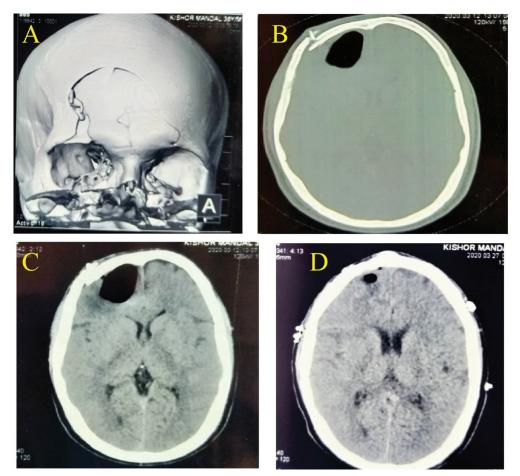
Preoperative 3D CT image showing frontal bone depressed fracture(R>L) (A), axial Ct image showing pneumocephalus (B, C) and Postoperative axial CT image showing elevated fracture with resolving pneumocephalus.
